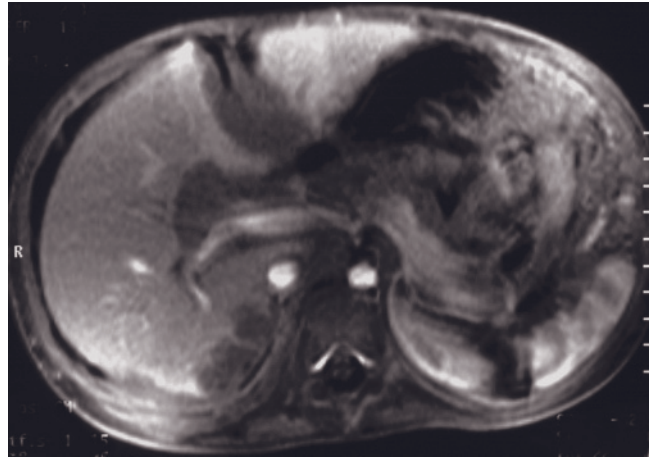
Burkitt lymphoma with periportal infiltration. Coronal T2-weighted SS-ETSE (a), fat-suppressed T2-weighted SS-ETSE (b), SGE (c), and immediate (d) and 90-s fat-suppressed postgadolinium SGE (e, f) images. There is extensive soft tissue infiltration in the porta hepatis with periportal extension (arrows, a, b). Periportal tumor infiltration is more common with lymphoma than with other forms of malignant disease. Retroperitoneal nodes are also present (f).
